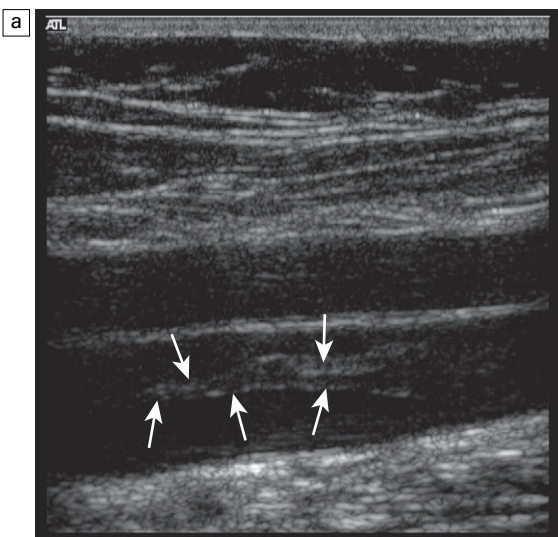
(a) A small tail of thrombus extending up the vein (arrows) which is not sufficiently large to produce any obstruction to flow and could be overlooked if visualisation of this area was poor; (b) power Doppler image of the same thrombus showing flow around it.
